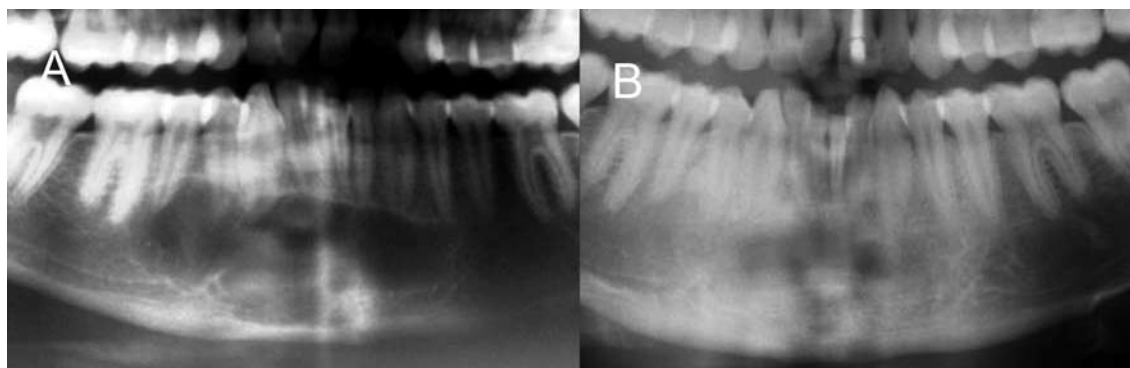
Traumatic bone cyst located in the region of the chin symphysis. A) Panoramic X-ray detail at the time of diagnosis. B) Panoramic X-ray detail one year after surgical treatment. Complete bone regeneration is observed.
